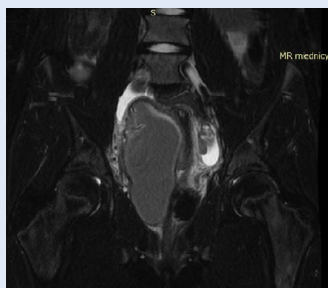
Magnetic resonance image showing uterus didelphys in OHVIRA syndrome
